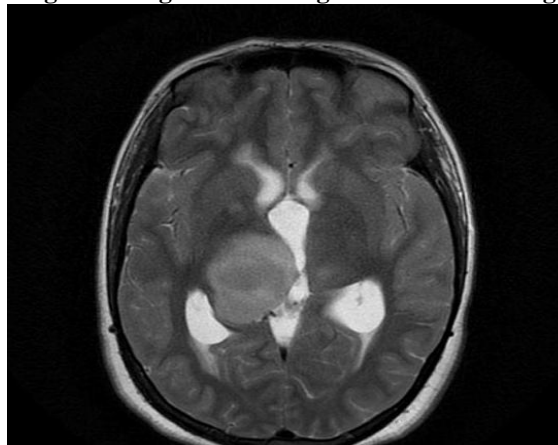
Right thalamic glioma MRI T1 image
